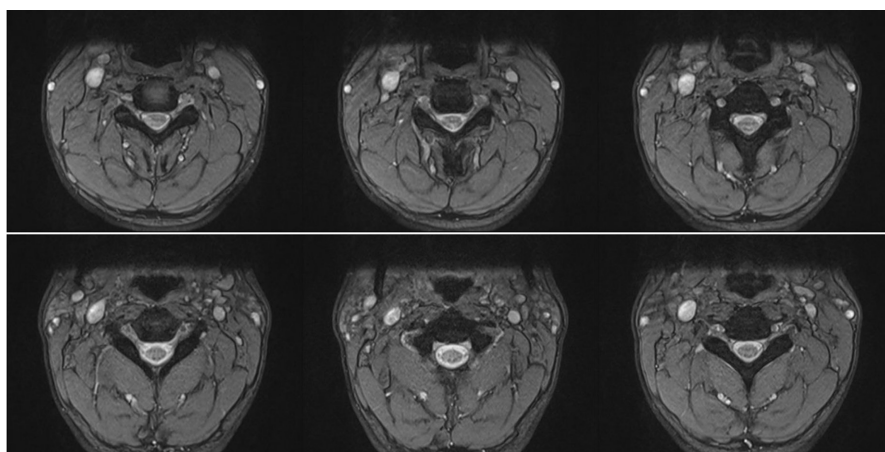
Spinal MRI with and without contrast injection. T2 axial, which shows a change in spinal cord signal.
